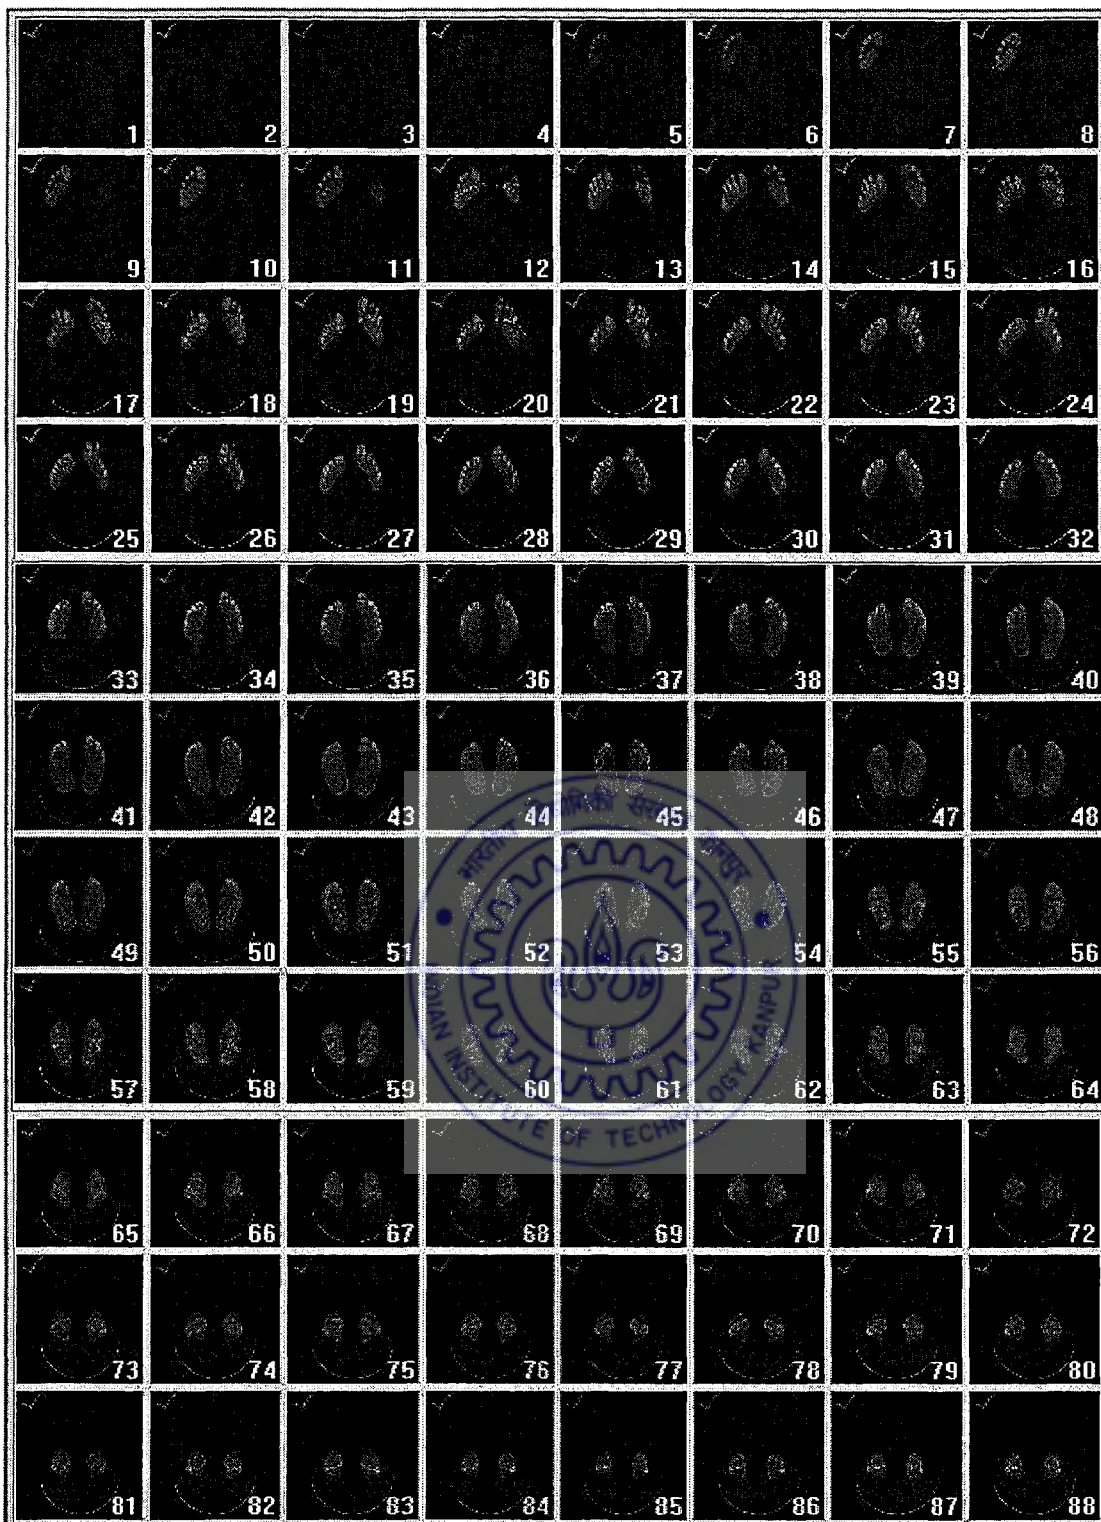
CT data of an adult foot in Mimics own proprietary format (mpj format)
